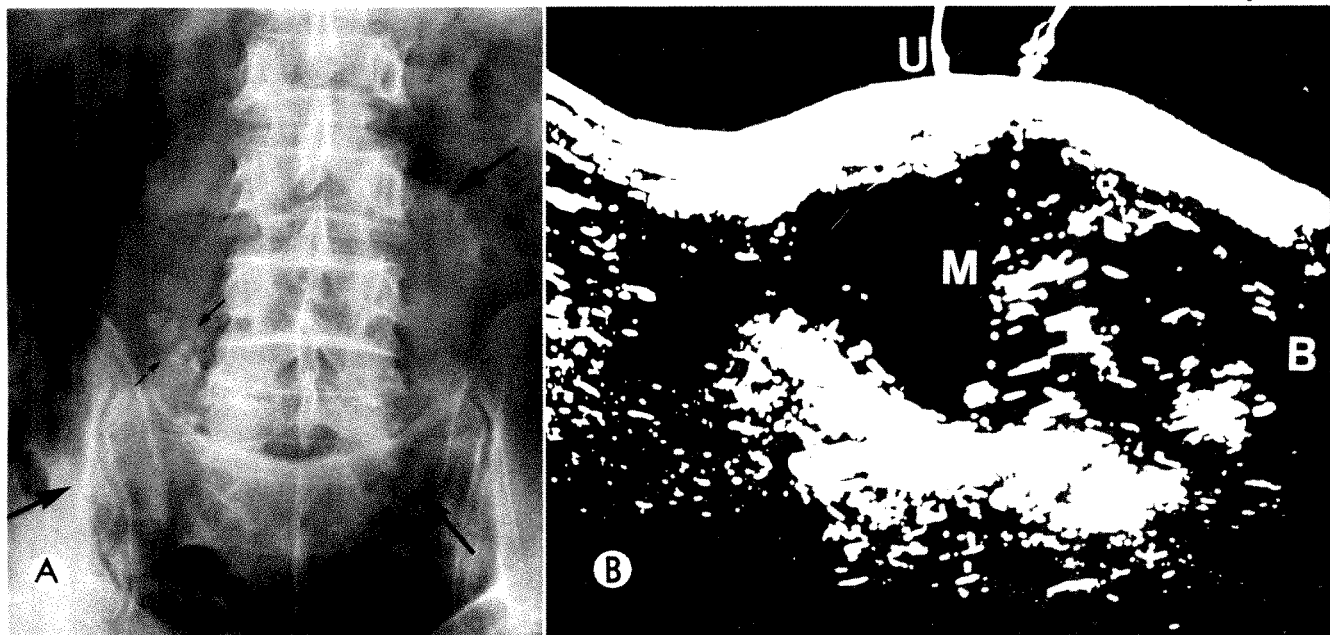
Case 2. A, Supine film of abdomen showing large soft tissue mass in supraventricular area (*large arrows*). Note several groups of fine calcification (*small arrows*) in mass. B, Longitudinal sonogram of abdomen at midline. M=mass, U=umbilicus, B=bladder. Note internal echoes within mass.
